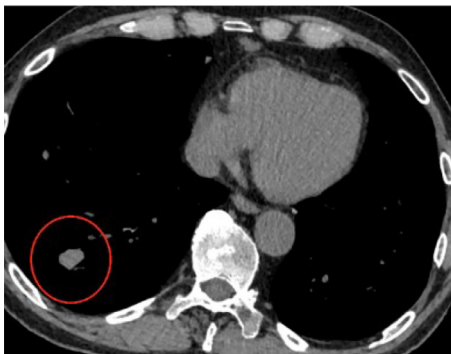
Chest CT with contrast, soft tissue window, showing hyperdense nodular opacity in right lower lobe circled in red.
